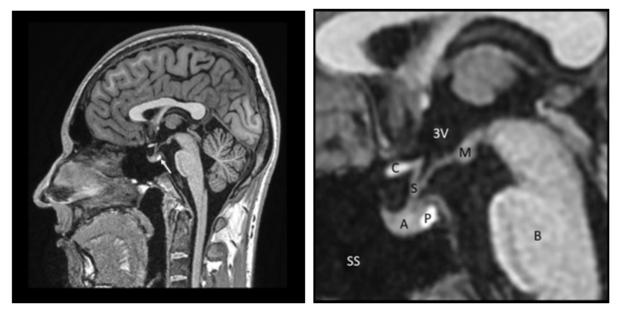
Sagittal T1-weighted image of the pituitary fossa demonstrates normal pituitary anatomy. The T1-weighted study is particularly helpful in identifying the posterior pituitary bright spot (white arrow)a focus of T1 signal hyperintensity posteriorly in the sella, which corresponds with the neurohypophysis. The intrinsic T1 signal shortening through the posterior pituitary is thought to be due to the presence of vasopressin. The zoomed image of the pituitary gland, consisting of the anterior (A) and posterior (P) lobes, sits within the sella turcica, a "saddle"-shaped depression in the sphenoid bone, with the tuberculum sellae anteriorly, and the dorsum sellae posteriorly. Superior to the pituitary gland is CSF within the hypophyseal and suprasellar cisterns. The pituitary stalk (S), also known as the infundibulum or infundibular stalk, extends through the suprasellar cistern, extending between the hypothalamus and the superior surface of the pituitary gland. The optic chiasm (C) can be seen in the suprasellar space more superiorly. Anteroinferior to the pituitary gland is the sphenoid sinus (SS). (B)- brainstem, (M)-mammillary bodies, (3V)- third ventricle.
